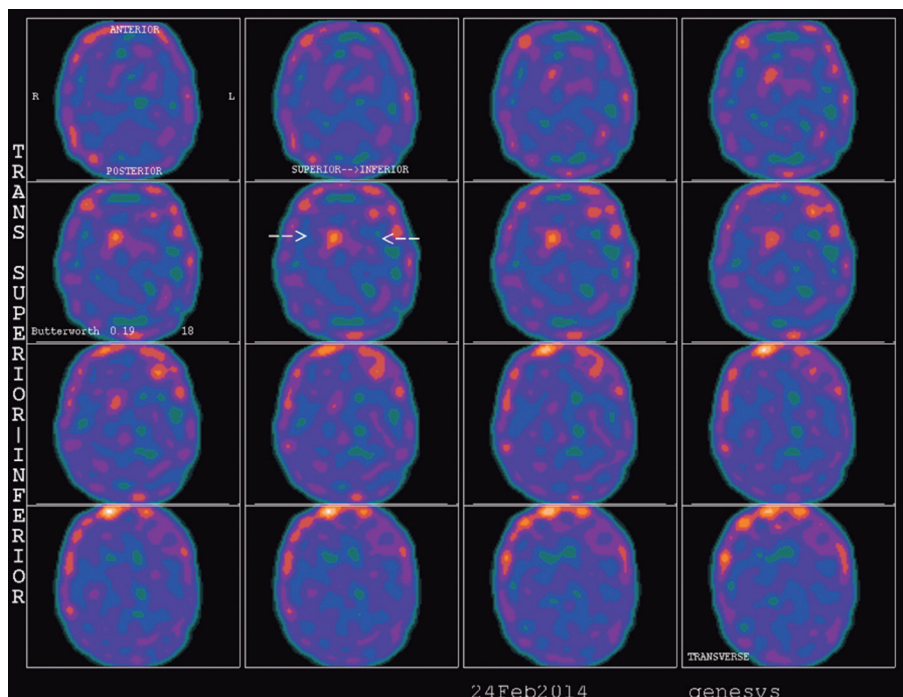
Single-Photon Emission Computed Tomography (SPECT) of patient using the radiotracer TRODAT showing right striatum of 0.84 (0.64-1.0) and left striatum <0.20 (0.64-1.0), suggestive of Parkinson's disease.
